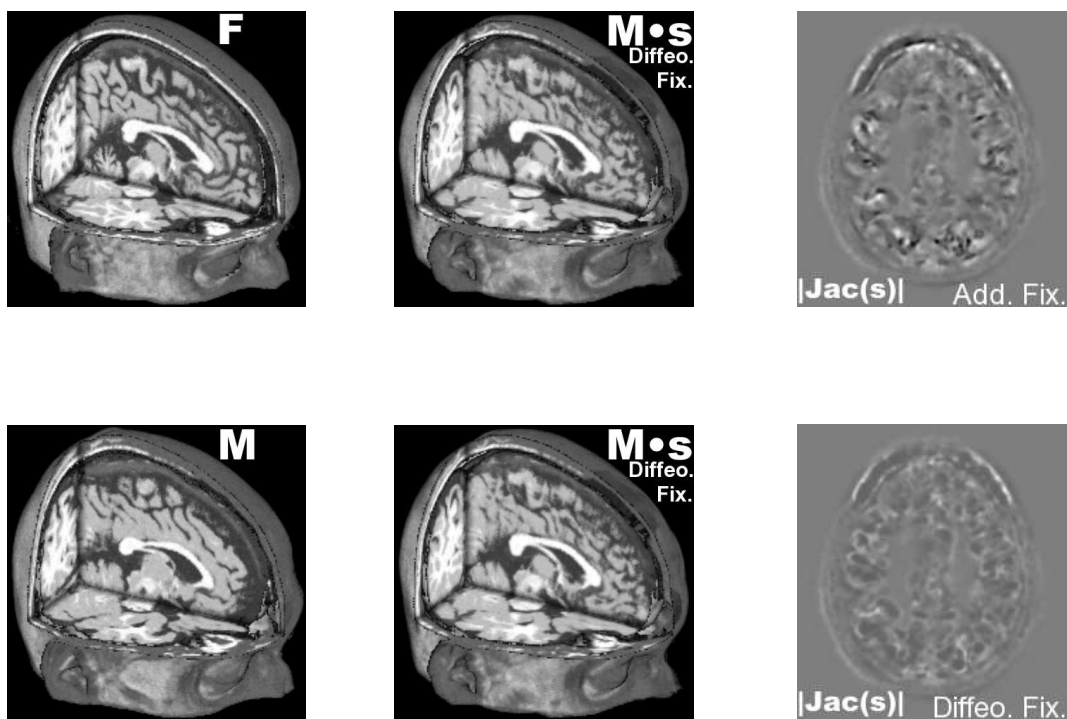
Registration of two synthetic T1 MR images of distinct anatomies from BrainWeb. For visually similar results, our diffeomorphic demons algorithm provides smoother and diffeomorphic transformations when compared to the additive demons algorithm.
